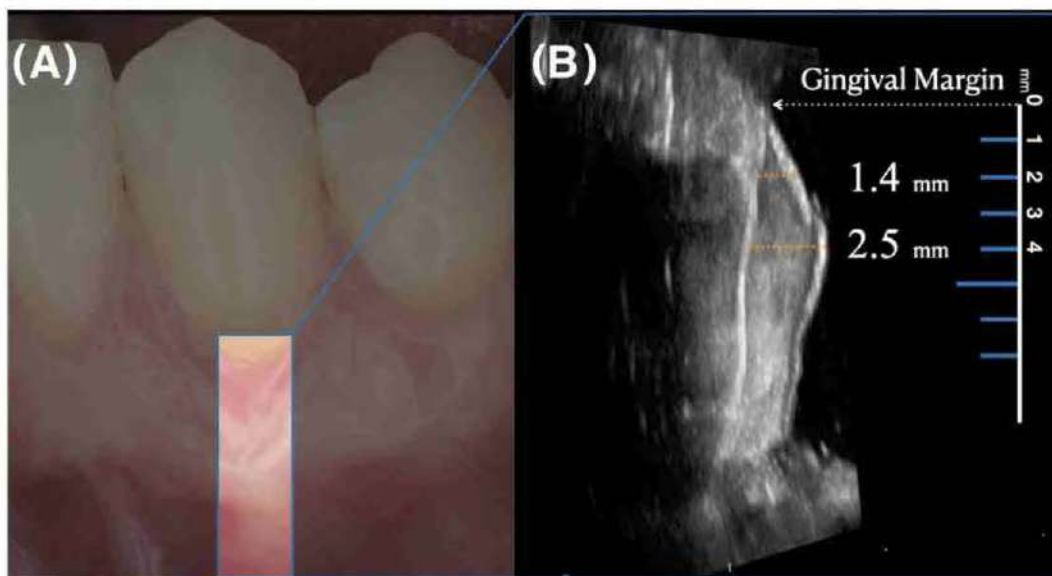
Ultrasound assessment of soft tissue thickness at the 15-month follow-up. (A) Clinical view. (B) Ultrasound image demonstrating successful graft integration and soft tissue thickness measurements of 1.4 mm and 2.5 mm at distances of 2 mm and 4 mm from the gingival margin, respectively.
